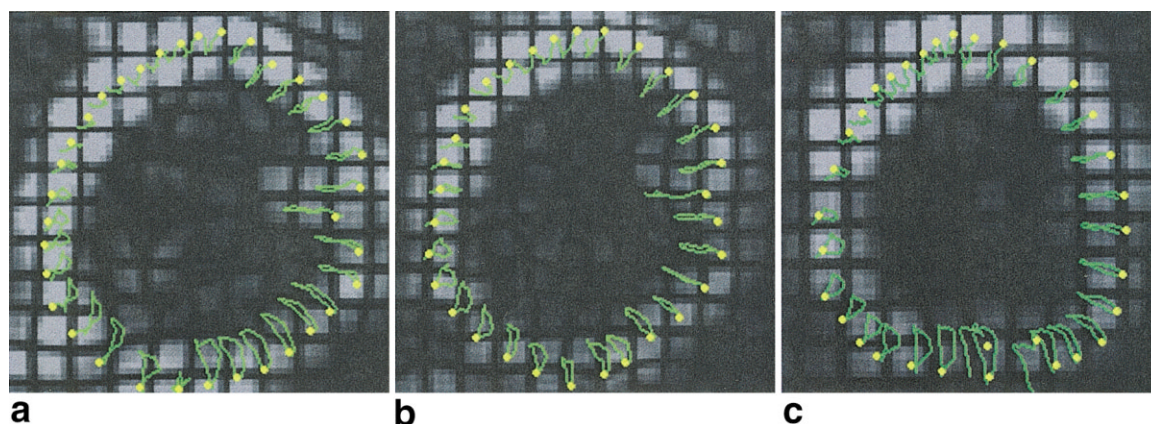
Tracked paths of randomly selected points in the myocardium at end-diastole for: (a) breath-hold HARP-MRI, (b) non-breath-hold HARP-MRI, and (c) conventional breath-hold 1-1 SPAMM sequence.
